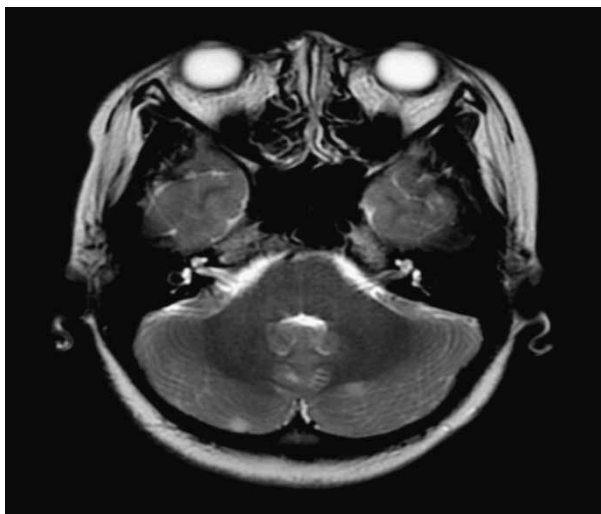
MRI showing T2 hyperintensities in bilateral cerebellar hemispheres in Patient 2
